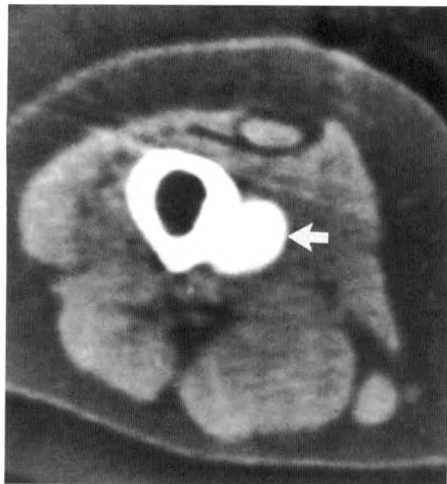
CT shows parosteal osteosarcoma of distal femur with localized and homogeneous calcification (arrow).
